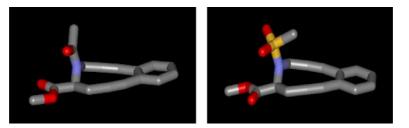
X-ray structures for enediyne acetamide 6 (left) and mesylate 7 (right).
